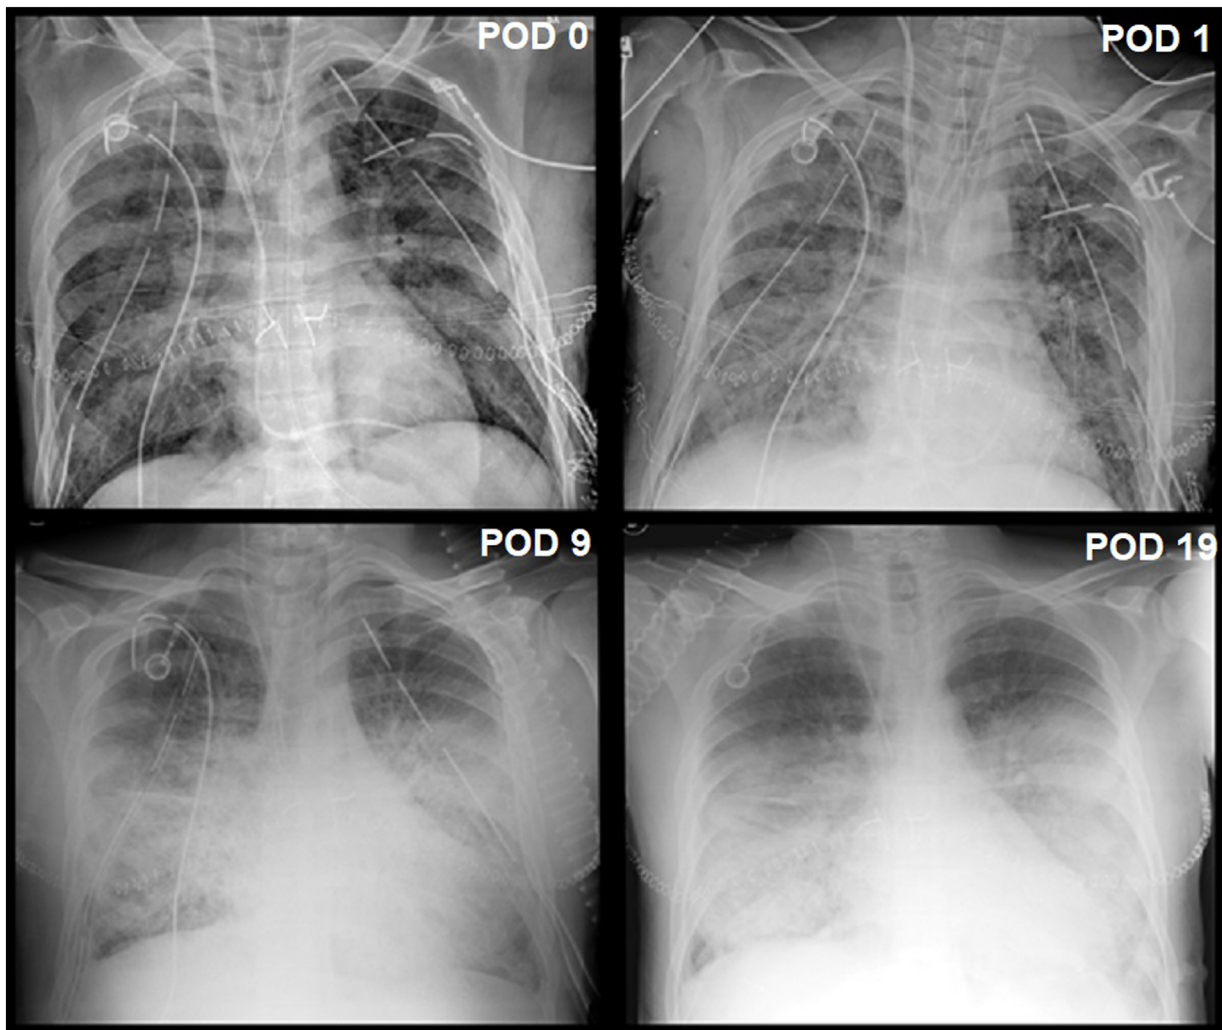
Post-transplantation chest x-rays.
